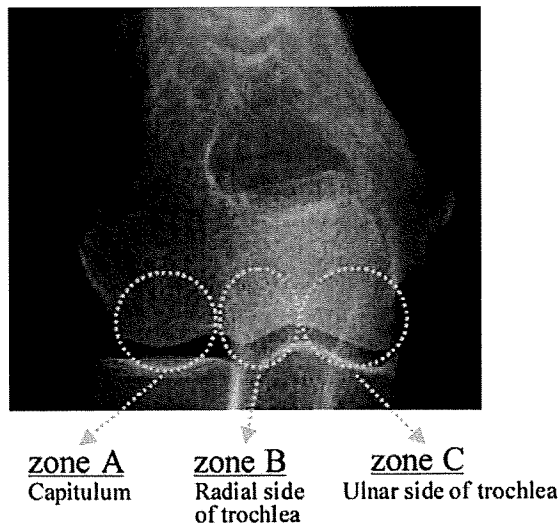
Radiographic classification (zones A, B, and C)
